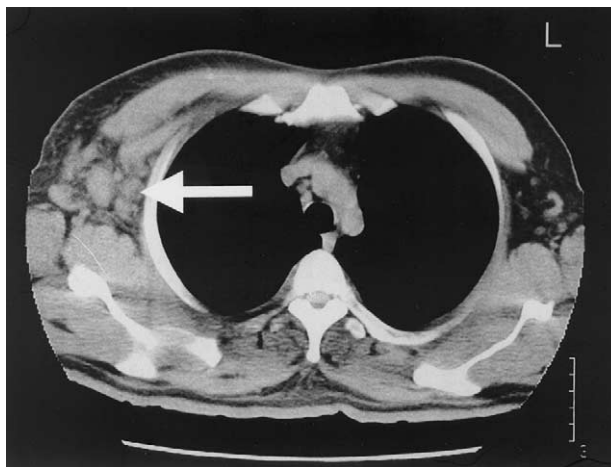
Computed tomographic image of the chest showing multiple discrete lymph nodes in the right axilla (arrow).
